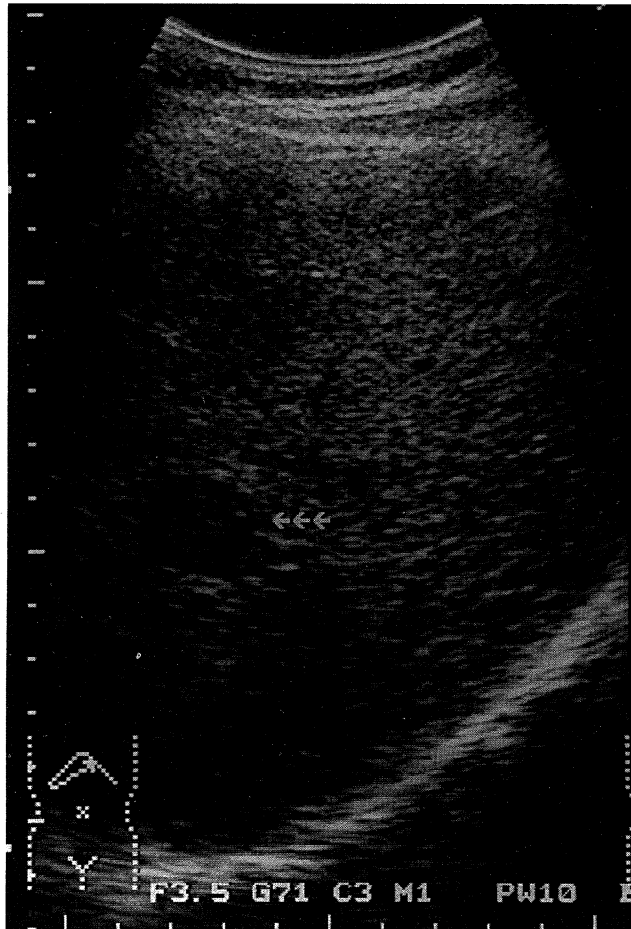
Ultrasonographic findings for case 2
